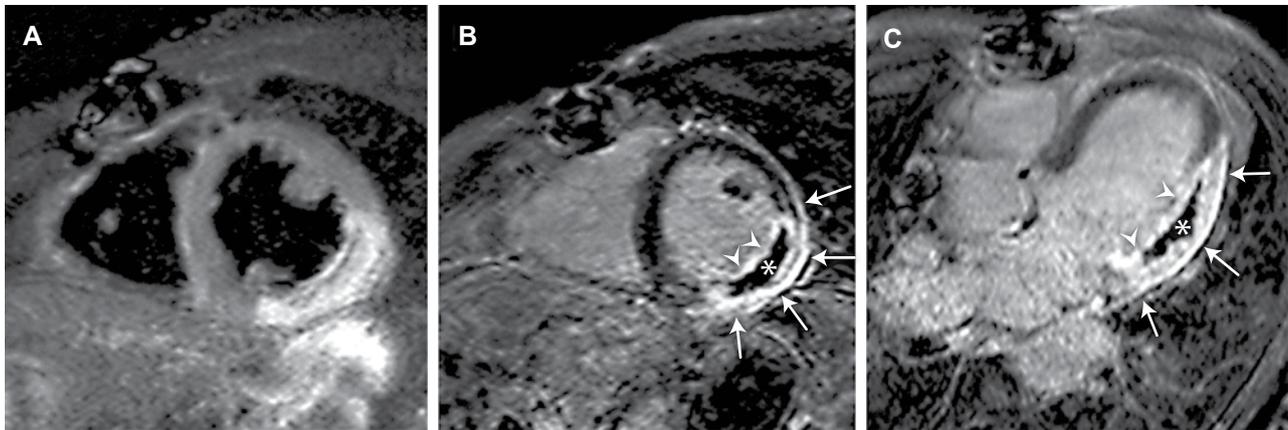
Cardiac magnetic resonance (CMR) findings. Comprehensive CMR performed 8 days after the acute event, including T2-weighted short- τ inversion recovery (T2W-STIR) imaging (A), with late gadolinium imaging in the short-axis (B) and horizontal long-axis (C) planes. The extend of edema can be well appreciated on T2W imaging of the inferior and inferolateral wall (A). Transmural enhancement on late gadolinium imaging at the inferolateral wall (arrowheads, B and C) is present, corresponding to the area of edema. The hypointense area within the infarcted myocardium is suggestive of an extensive no-reflow zone (asterisk, B and C). Strong pericardial enhancement along the inferolateral wall (arrows, B and C) confirms the presence of regional pericardial inflammation.
